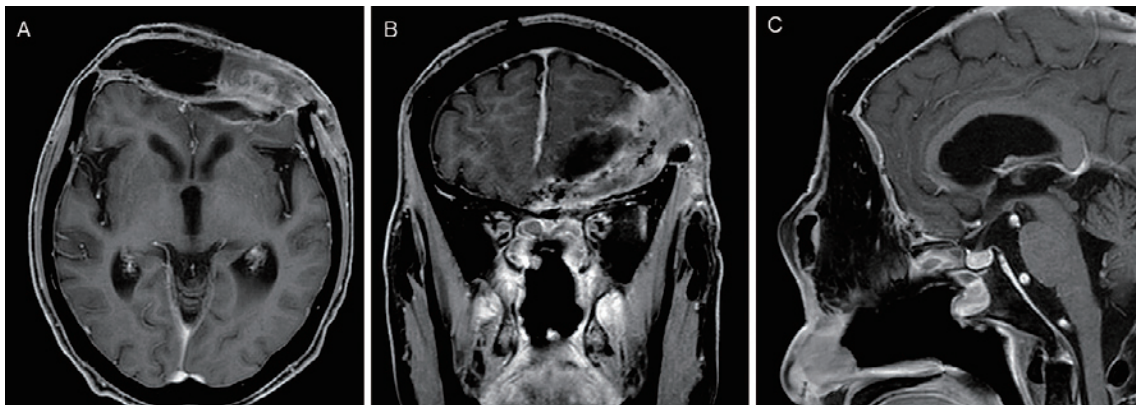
Postoperative post-gadolinium enhanced MRI 2 months after en bloc resection.
